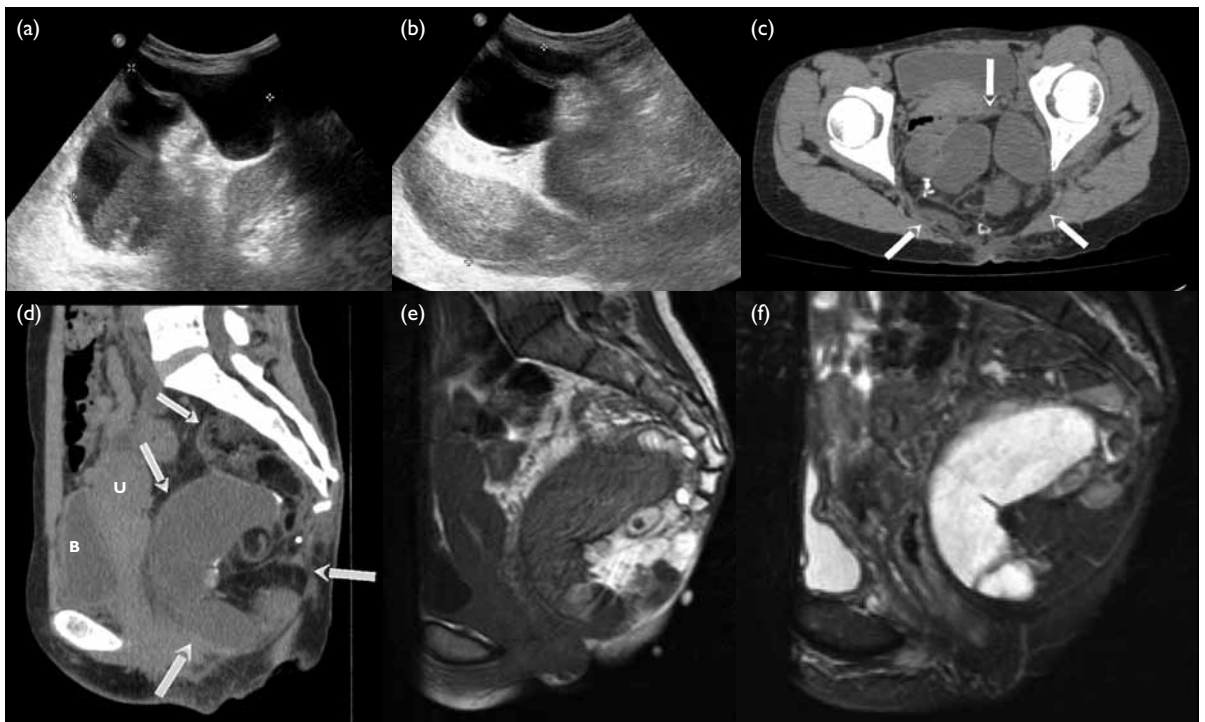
Ultrasound images of the left buttock showing (a) a large complex mass with cystic and soft tissue components, and (b) a heterogeneous lesion at the left buttock with cystic components (top layer), fat (middle echogenic layer) and soft tissue components (bottom layer). (c) Axial computed tomography (CT) pelvis obtained at the level of the acetabulum showing a heterogeneous mass (arrows) with cystic components in the retrorectal space extending into the left ischiorectal fossa. Fat, soft tissue, and calcification were noted within the lesion. Displacement of the rectum anteriorly and to the right was evident. (d) Midline sagittal CT pelvis showing an irregular mass lesion (arrows) anterior to the sacrum and coccyx extending inferiorly. It appeared to displace the vagina anteriorly and compressed the urinary bladder (U: uterus, B: urinary bladder). (e) Midline sagittal T1 magnetic resonance (MR) image of the pelvis and (f) midline sagittal fat saturated T2 MR image of the pelvis showing a heterogeneous mass occupying the presacral space, that seemed to displace the rectum anteriorly. Cystic areas with homogeneous contents were seen. The anterior cystic components showed T1 hypointense signals and T2 hyperintense signals, indicating serous fluid. T1 hyperintense areas, which were suppressed on the fat saturated sequence, were seen at the posterior aspect of the lesion, indicating fat content
